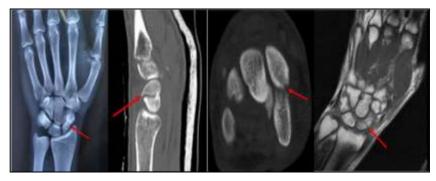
(A) X-ray AP view of right wrist showing transverse fracture through the scaphoid bone (red arrow). (B) CT Sagittal images of same patient showing fracture through the scaphoid bone (red arrow). (C) MRI T1WI Axial and Sagittal images demonstrating breach in scaphoid bone (red arrow)
